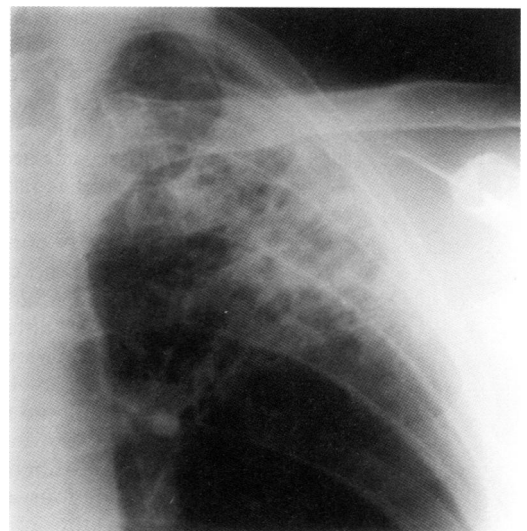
Chest radiograph of a patient with tuberculosis showing a large cavity in the left upper lobe containing an air fluid level, a feature not seen in *M kansasii* infections.
